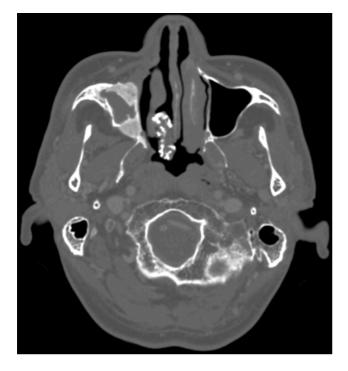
On computed tomography scan, a 2.8 cm-sized calcified lesion is observed posterior to the inferior turbinate of the right nasal cavity and fibrous dysplasia of the ipsilateral maxillary sinus.
